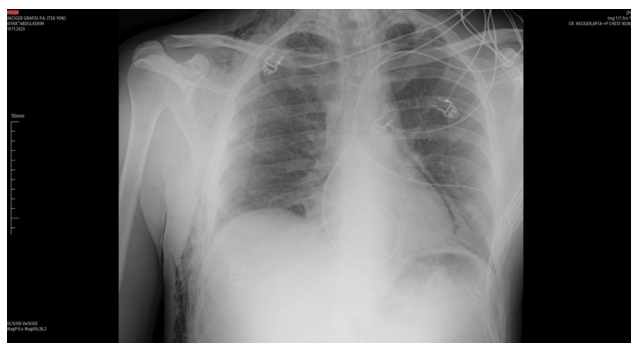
Pneumomediastinum on PA chest radiography case records were carefully reviewed, taking into account demographic data, symptoms, precipitating
